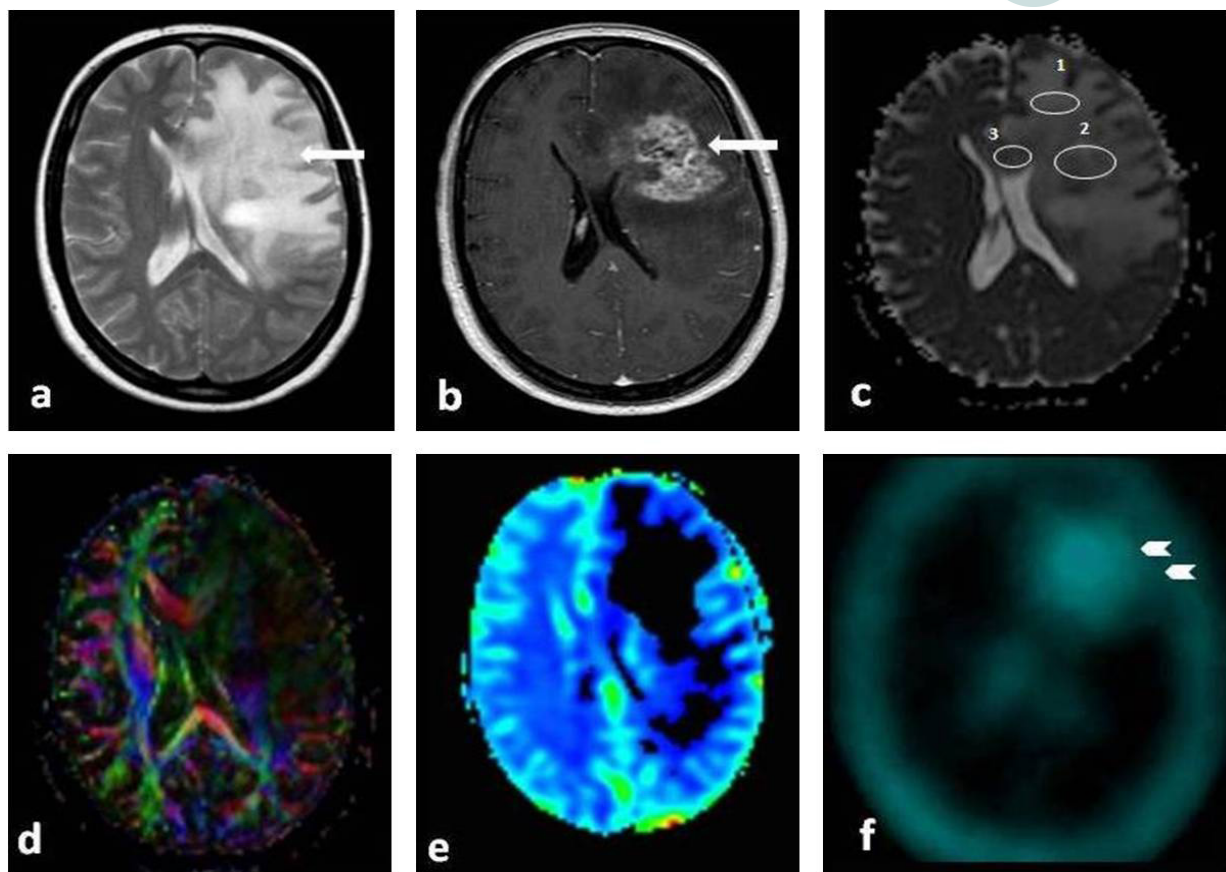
T2-W axial images (a), T1-W axial images with intravenous contrast administration (b), demonstrated an extensive edematous lesion with mass effect and heterogeneous enhancement (arrows), characteristic of both tumor recurrence and radiation necrosis. The diffusion weighted imaging (DWI) demonstrated decreased values of the apparent diffusion coefficient (ADC) maps (c) ($1.2\text{--}1.8 \times 10^{-3} \text{ mm}^2$) consistent with malignant tumor infiltration. However, the fractional anisotropy (FA) (d) maps showed increased white matter tracts destruction (low FA) and the perfusion maps (CBV) (e) depicted very low perfusion, both consistent with radiation-induced necrosis. SPECT (f) revealed increased metabolic activity (arrowheads) consistent with tumor recurrence
